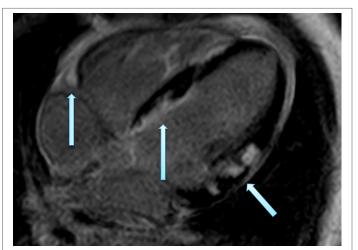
Cardiac magnetic resonance imaging showed extensive transmural enhancement
